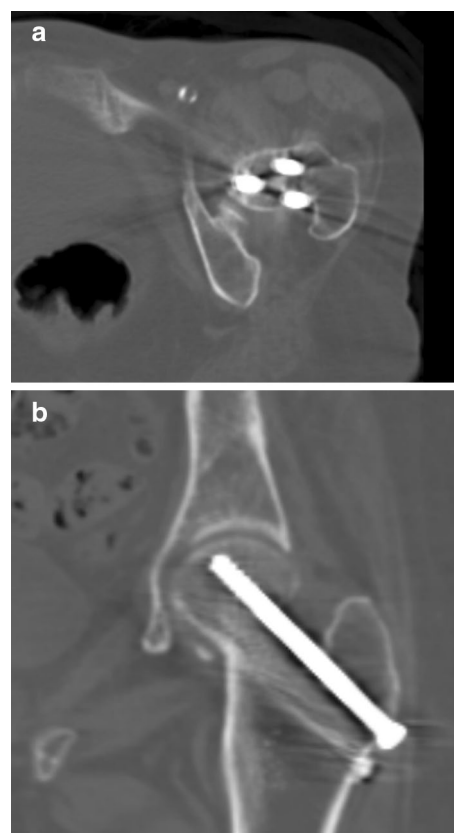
Axial (a) and coronal (b) reconstructions of the pelvis obtained 14 months after surgical fixation. The CT scan was obtained as part of an evaluation after another fall. The CT confirms the posterosuperior screw is extraosseous. The patient went on to uneventful union without evidence of osteonecrosis
